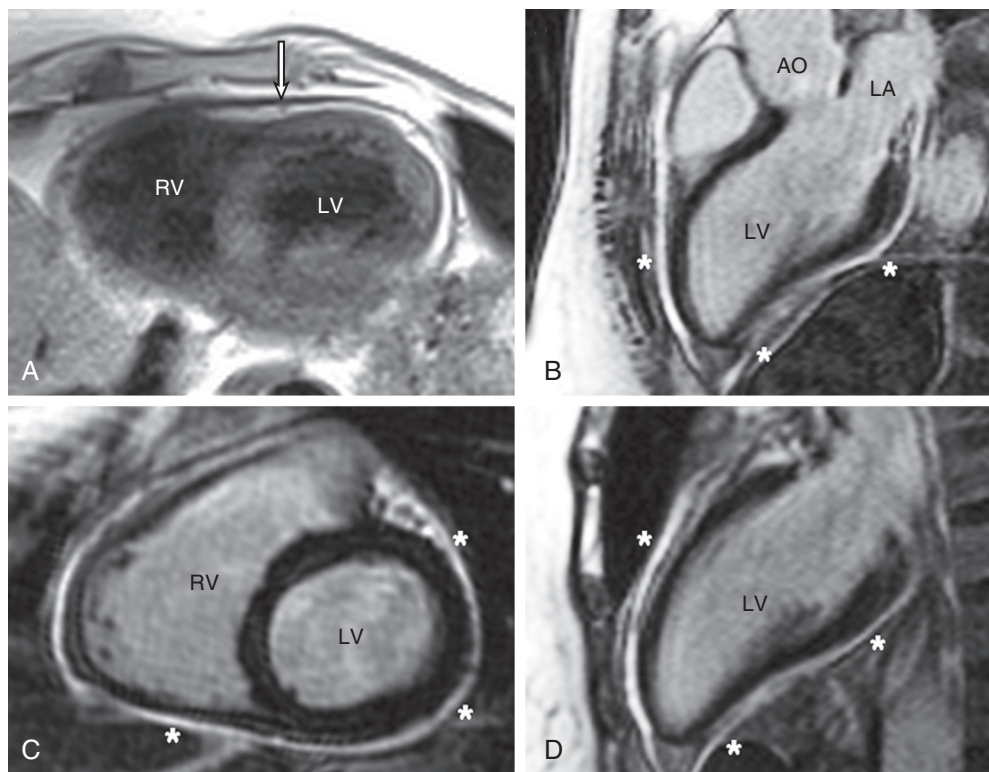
Pericardial inflammation by CMR. The patient was a 43-year-old woman with systemic lupus and a history of pericarditis in whom CMR imaging showed pericardial constriction. A, The pericardium is thickened and enhanced on T2-weighted images (arrow), as well as on LGE sequences (asterisks) in multiple imaging planes (B-D). AO = aorta; LA = left atrium; LV = left ventricle; RV = right ventricle.
